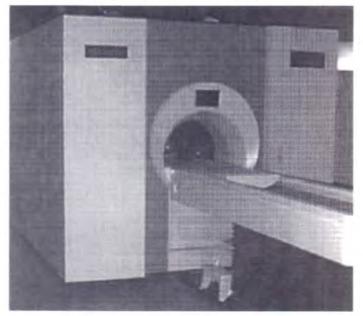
The new 4-Tesla Varian functional Magnetic Resonance Imaging machine in the Cuddy Wing of the Robarts Research Institute.
